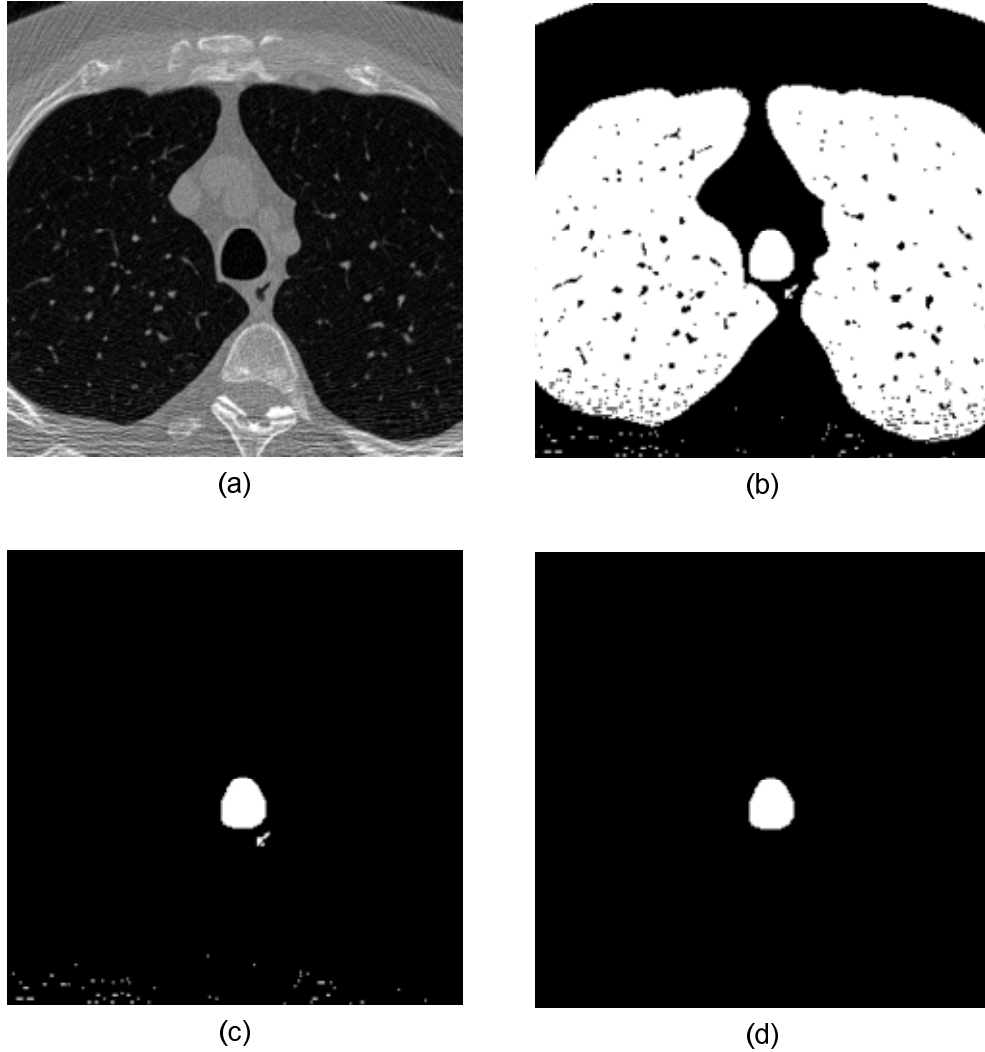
Seed point detection. The images at different stages are shown: (a) the clipped region of the CT image. (b) the image after thresholding and negating at -600 HU. (c) the image after performing connected component analysis and border-touching component removal. (d) the largest region among the remaining components.
